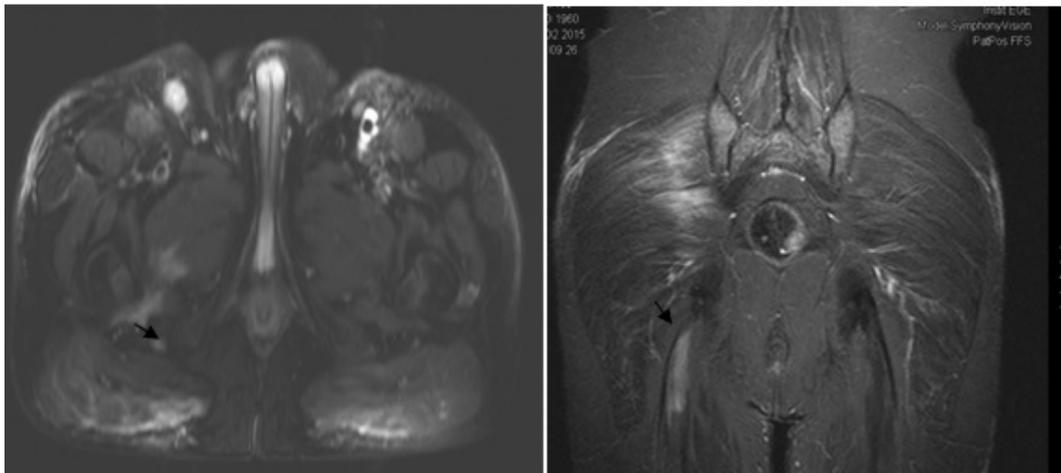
Thickening and edema of the right sciatic nerve seen as hyperintense on hip MRI (black arrow).
